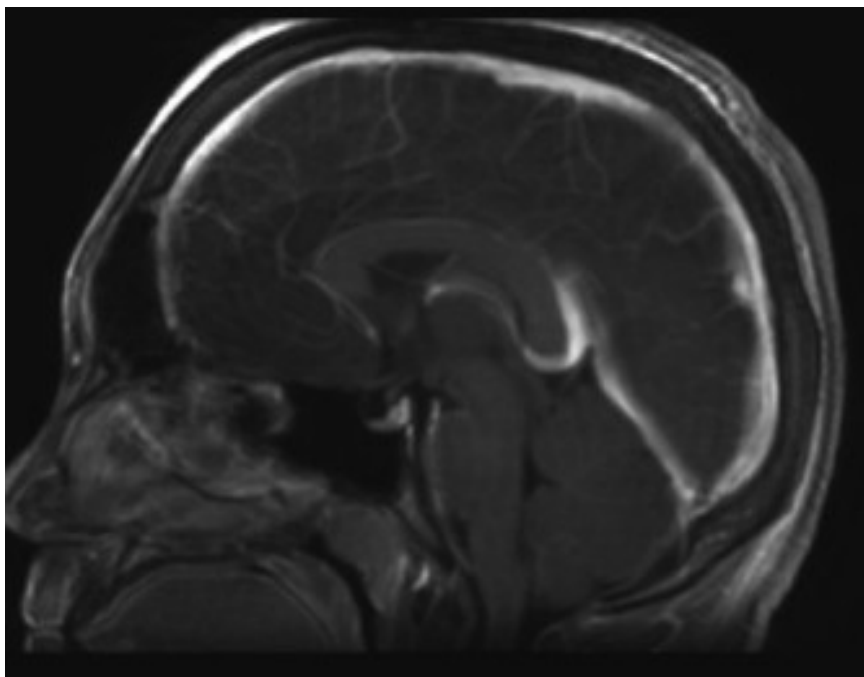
Sagittal MRI brain (enhanced) shows complete recanalization of the sagittal sinus.
